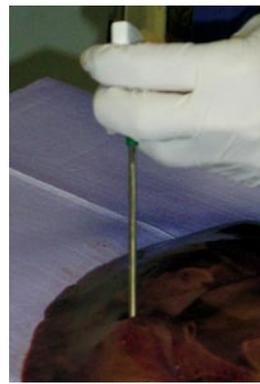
A 7-gauge biopsy needle and a syringe were used for insertion of the gelatine/FDG mixture into the liver. The mixture hardened as it cooled in the *ex-vivo*-liver.
